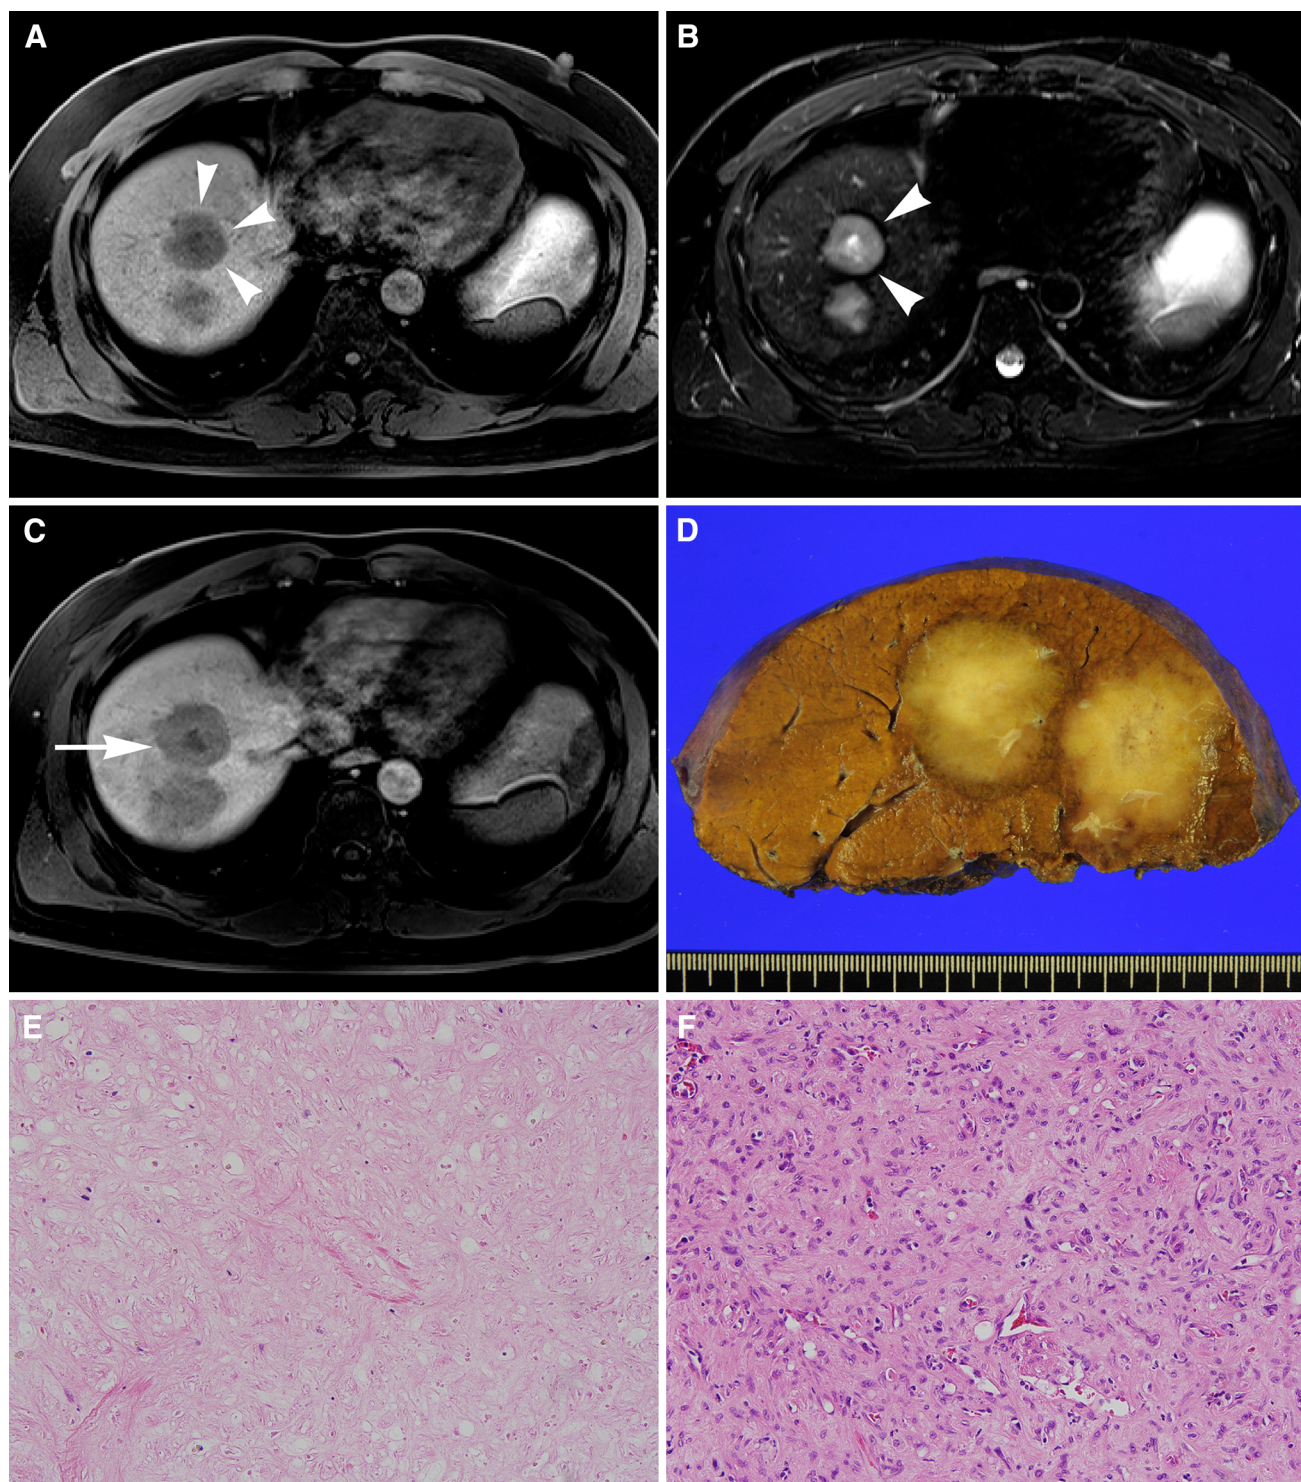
A 42-year-old male patient who underwent surgical resection. T1- (A) and T2-weighted images B show a round mass with a subtle hyperintense rim (*arrowheads*) and a definite hypointense rim (*arrowheads*) around the tumor. Hepatobiliary phase after administration of Gd-EOB-DTPA C shows a central hypointense core (core pattern; *arrow*). On
